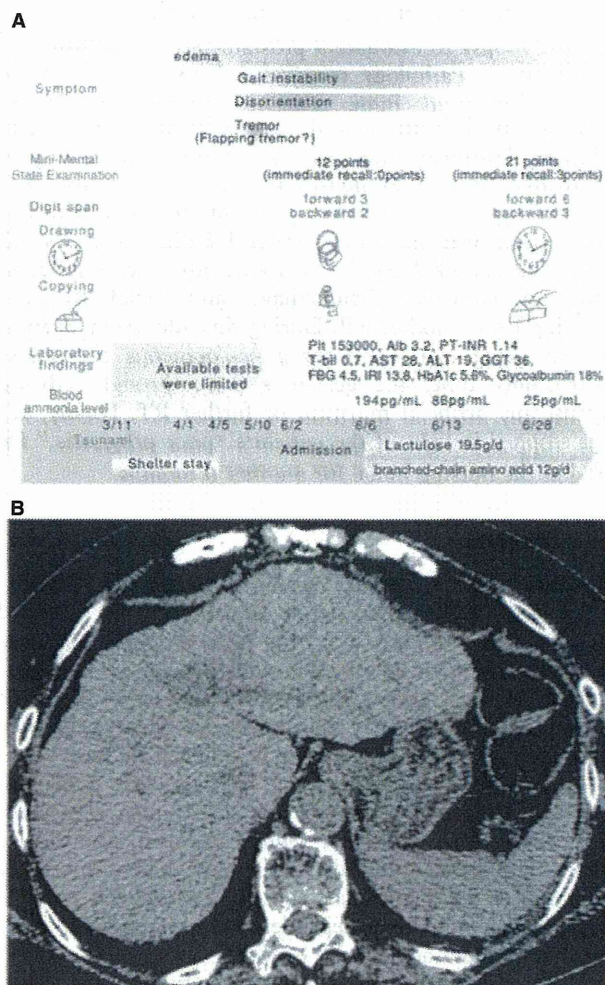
Clinical course and abdominal computed tomography of the patient. (A) Homeostasis model of assessment—insulin resistance (HOMA-IR) was calculated as 2.76, indicating high insulin resistance. Discrepancy between glycohemoglobin and glycoalbumin was observed. (B) Liver density was higher than fat density, indicating that fibrosis had already progressed. Splenomegaly, ascites, bile duct abnormalities, and collateral circulation were absent. Liver dysfunction caused by metal deposition was excluded, because the liver density was equivalent to that of the spleen; platelets 153,000/ μ L, albumin 3.2 g/dL, prothrombin time international normalized ratio 1.14, total bilirubin 0.7 mg/dL; aspartate aminotransferase 28 IU/L, alanine transaminase 19 IU/L, gamma-glutamyltranspeptidase 36 IU/L, fasting blood glucose 4,5 mmol/L, insulin resistance index 13.8 μ U/mL; glycosylated hemoglobin 5.6%.
